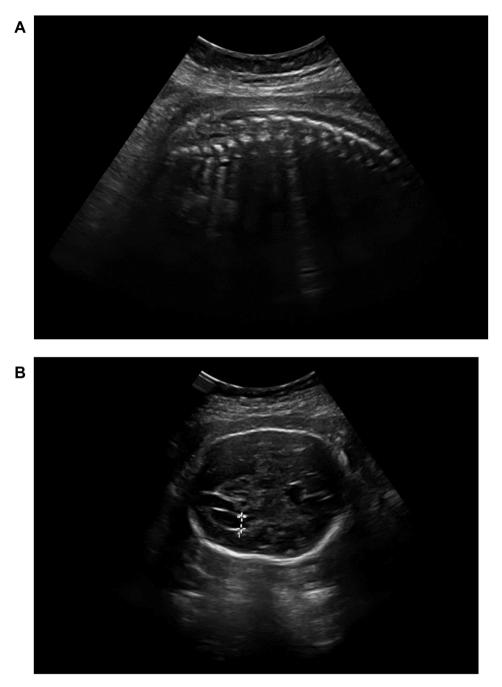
A. Ultrasound scan of the fetus at 30 weeks: fixed Myelomeningocele. B. Ultrasound scan of the fetus at 30 weeks: slightly dilatated the third ventricle.
